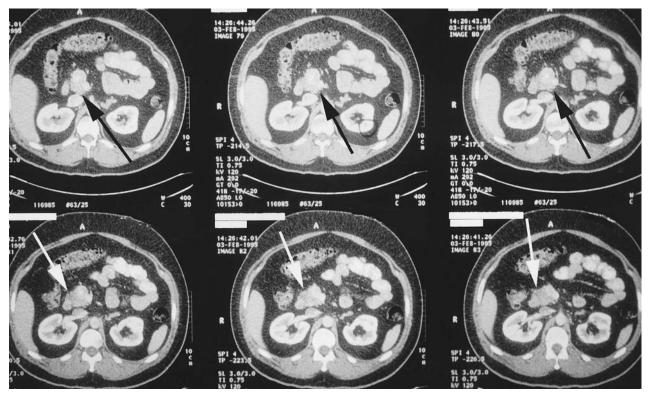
Computed tomographic scan of the pancreas in a patient with multiple endocrine neoplasia (MEN) type I and a nonfunctioning tumor of the head of the pancreas. This patient was investigated because of his membership in a kindred with MEN type I and an elevated pancreatic polypeptide level. This otherwise asymptomatic tumor was resected by pancreaticoduodenectomy, and the patient is disease free at 4 years. The *arrow* indicates the neoplasm in the head of the pancreas.
